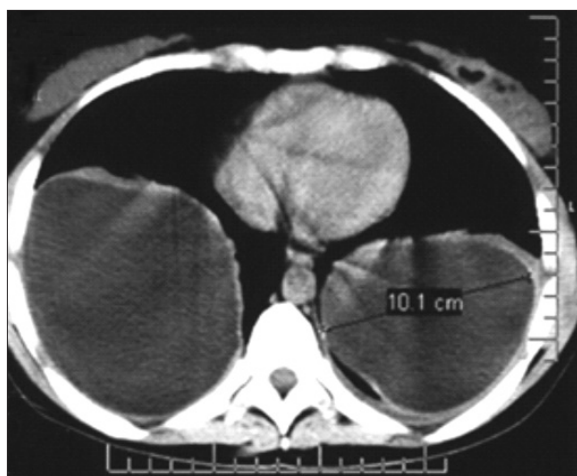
Chest CT showing bilateral hydatid cysts
